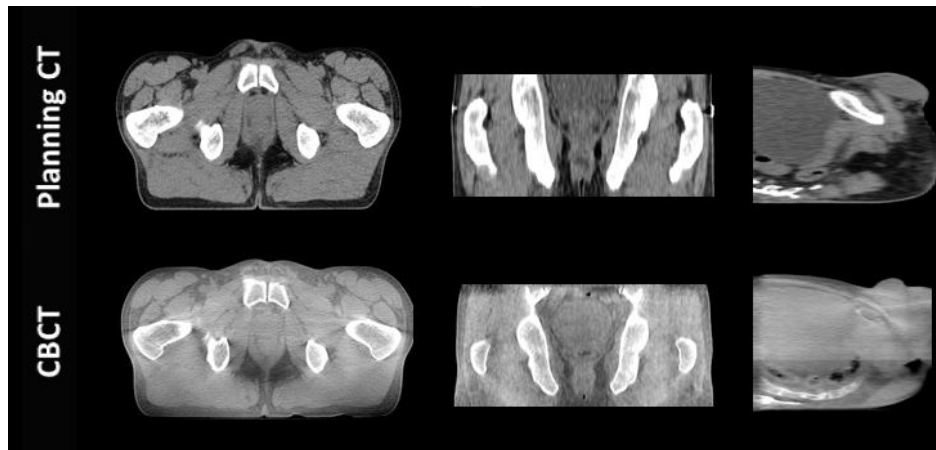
pCT and CBCT for the same patient (axial, coronal and sagittal views) displayed using the same window level.
